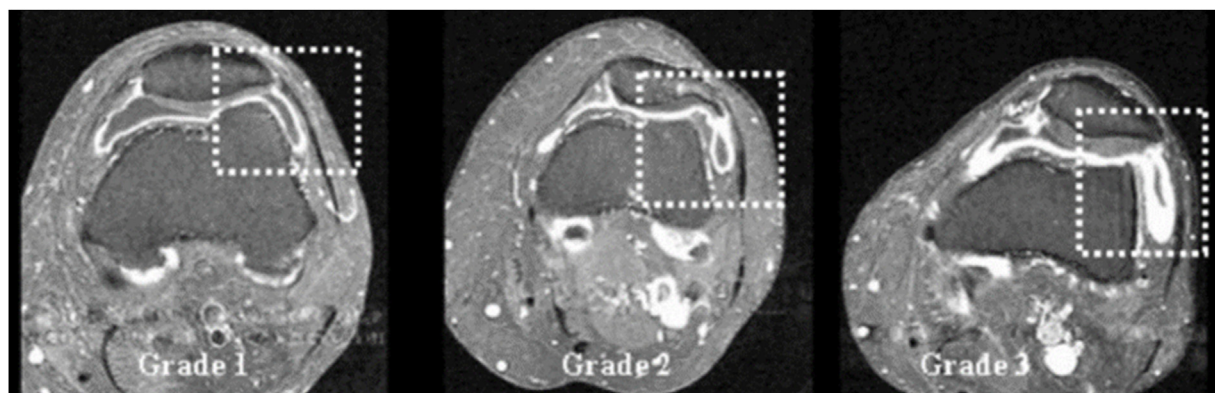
Adapted from Rhodes et al., 2005 The validation of simple scoring methods for evaluating compartment-specific synovitis detected by MRI in knee osteoarthritis. Contrast-enhanced T1-weighted post-gadolinium fat-saturated images demonstrating increasing SQ grades (left to right) of synovitis in the lateral parapatellar pouch of a patient with knee OA.
